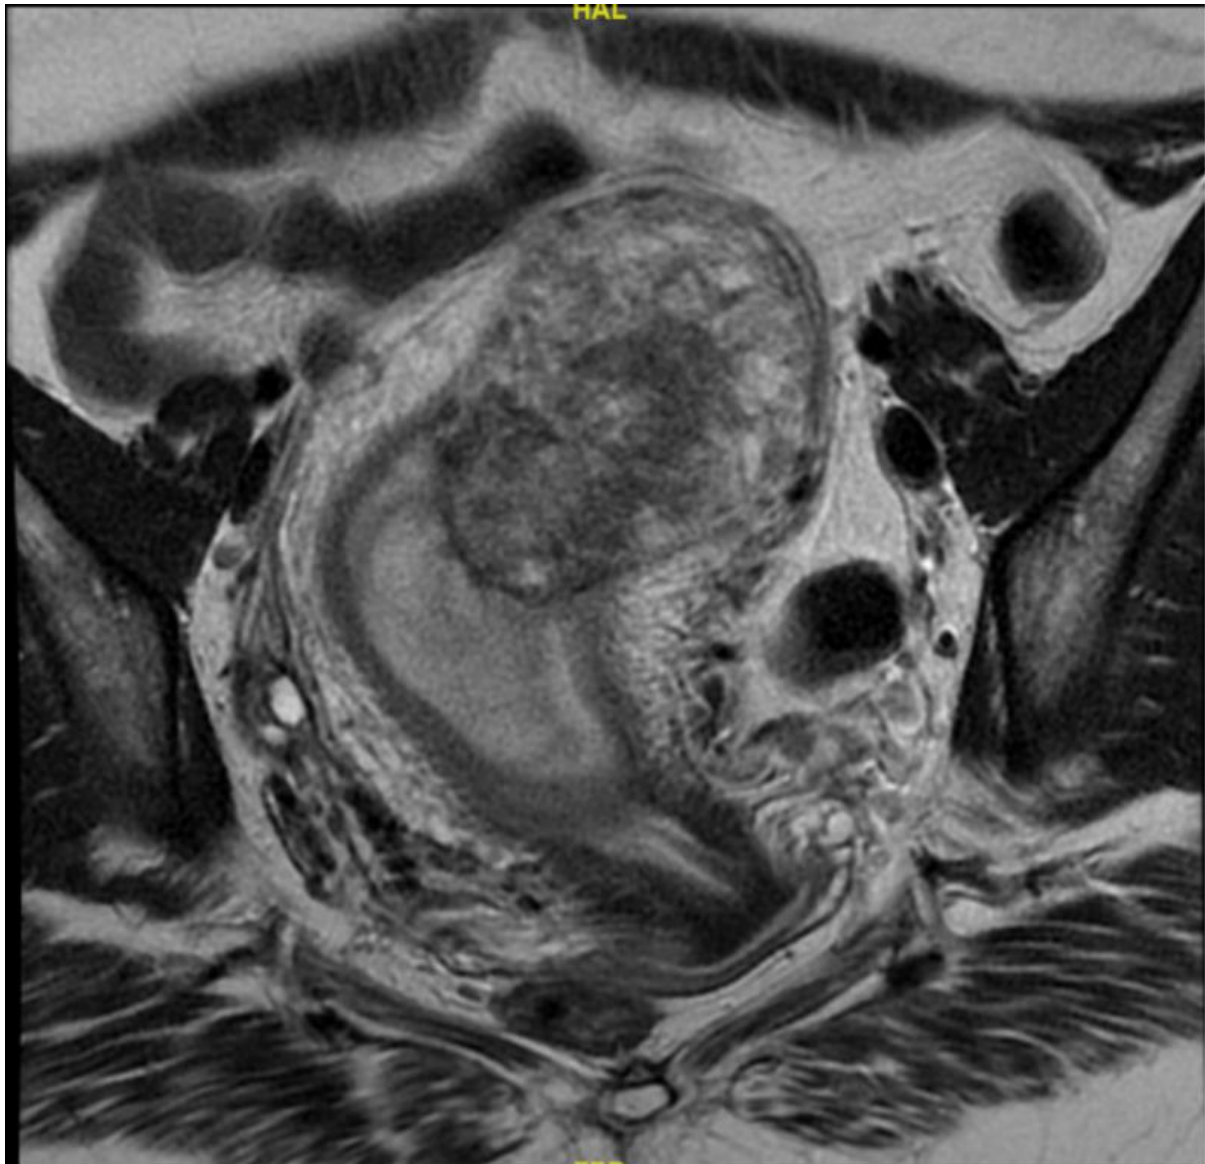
MRI pelvis showing 6.0x6.4x5.6cm mass in the uterine fundus
